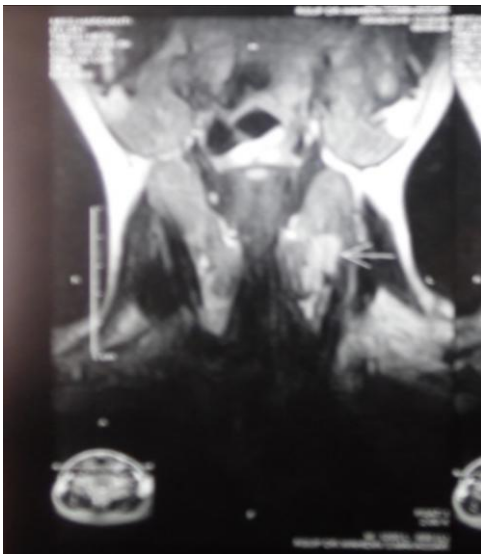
MRI showing left parathyroid lobe mass
